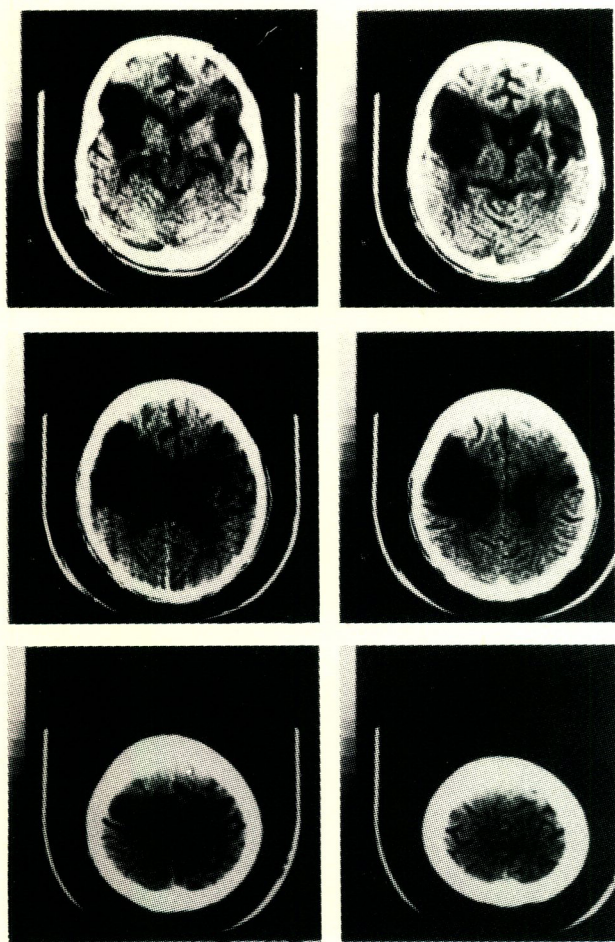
CT Scan of brain showing bilateral cerebral infarction.
